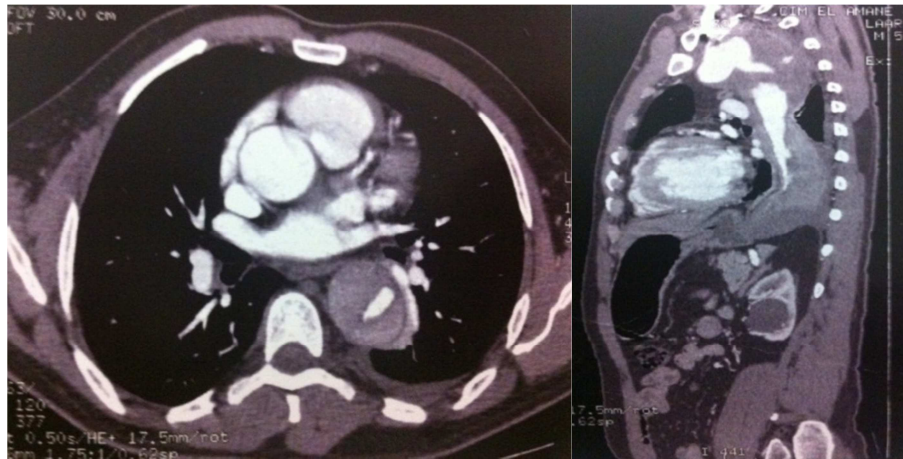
CT scan: before intervention.
